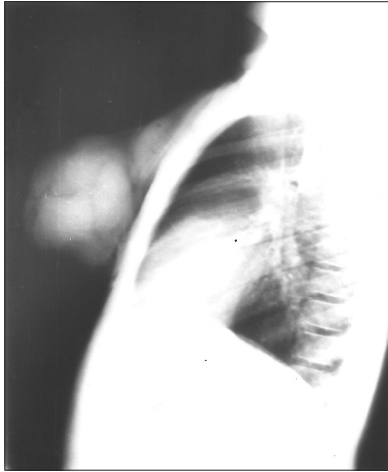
Lateral plain chest radiograph showing a lobulated soft tissue mass anterior to the sternum. Note that the lung fields are not involved
